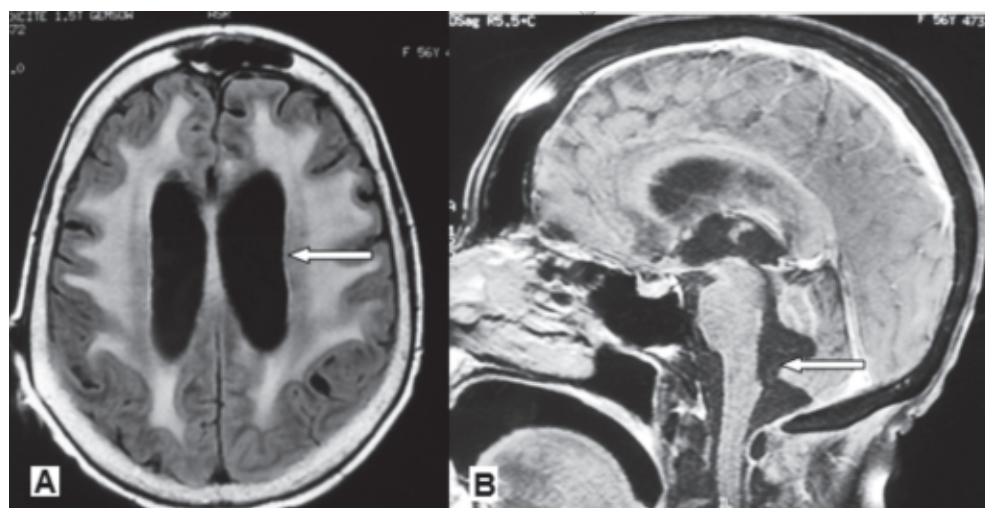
Image of MRI, to observe: A. Hydrocephaly and transependymary migration of CSF (arrow). B. Trapped fourth ventricle, characterized by dilation of the structure (arrow).
